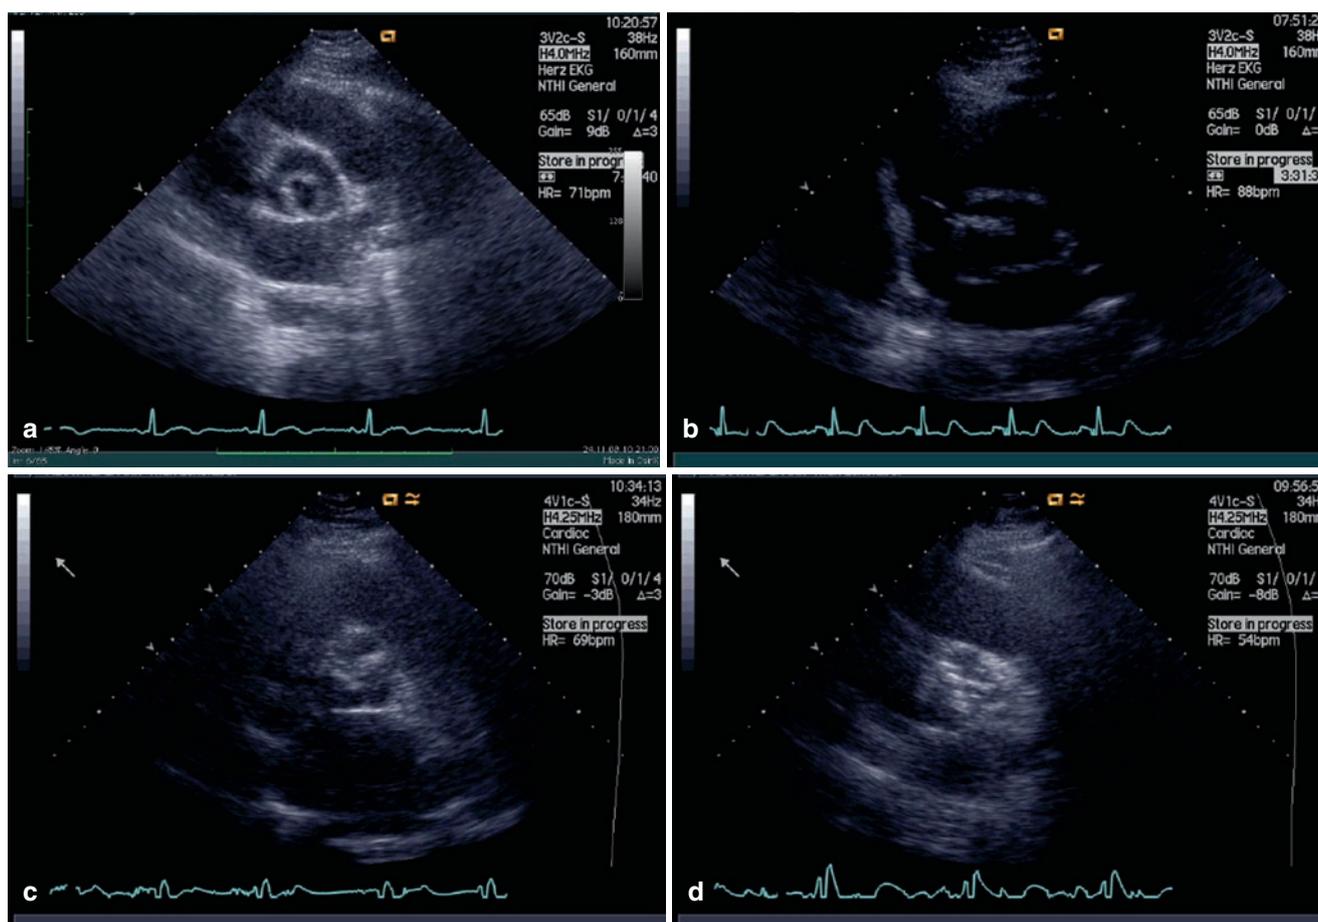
Degree of aortic valve calcification. (a) Parasternal short-axis view of a unicuspid stenotic aortic valve without calcification. (b) Parasternal short-axis view of a bicuspid AS with minimal calcification.
